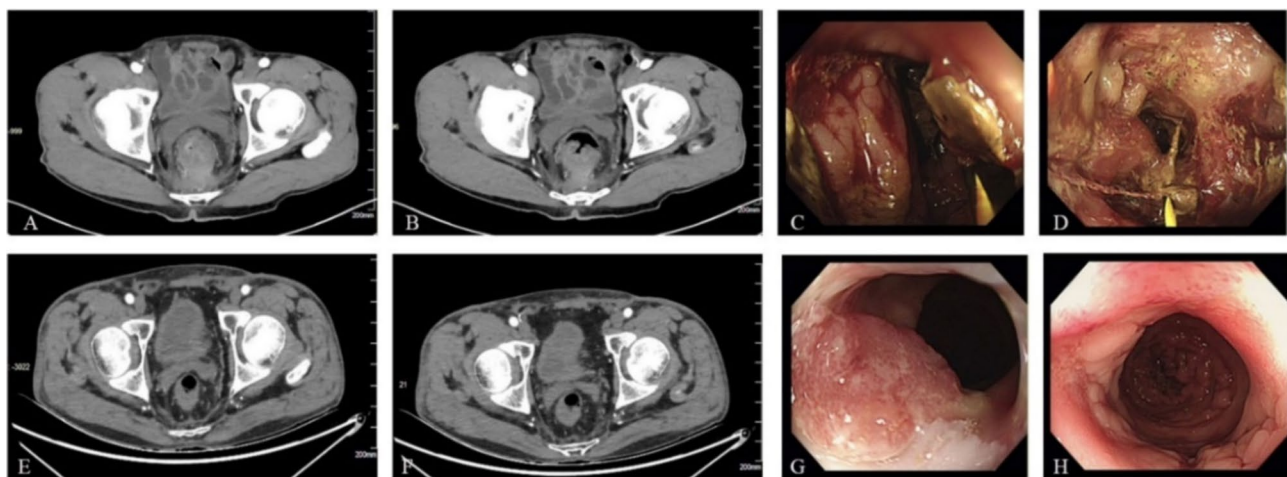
Enhanced CT and electronic colonoscopy examination results of the rectal cancer patient before and after treatment. (A, B) Enhanced CT before treatment showed uneven thickening of the intestinal wall extending from the lower rectum to the anus, accompanied by intestinal stenosis. (C, D) Electronic colonoscopy before treatment showed ulcerative protrusion lesions located 1 cm away from the anal with a diameter of approximately 5 cm and circumferential growth, resulting in significant lumen stenosis and deformation. (E, F) Enhanced CT at 3.5 months post-surgery exhibited reduced thickness of the intestinal wall from the lower rectal to the anus. (G, H) Electronic colonoscopy at 3.5 months post-surgery indicated shrinkage of the ulcer lesion located 1 cm from the anal opening, presenting a granular surface with a maximum diameter of about 1.5 cm
